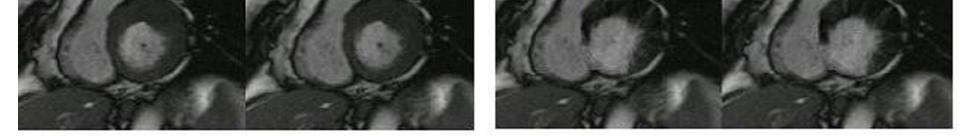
The cine MR images and the cine CE MR images. The six images on left are cine images. Their corresponding warped contrast-enhanced images are shown on the right.
